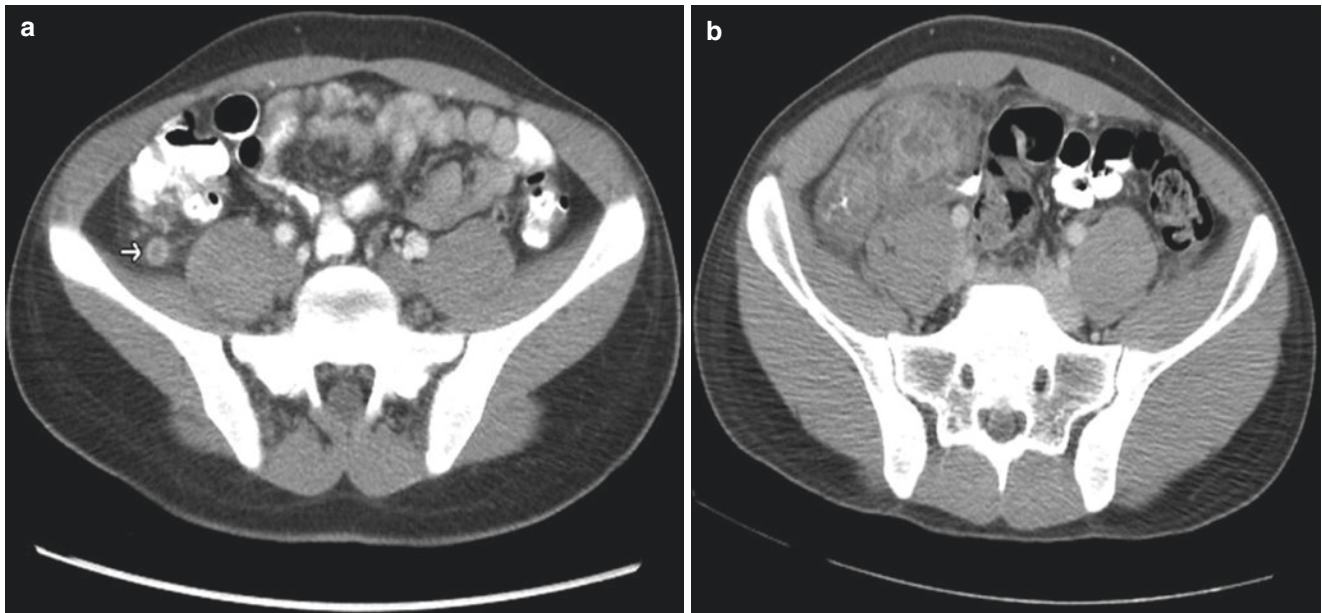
(a) A target sign on CT scan of the abdomen and pelvis consistent with acute appendicitis. (b) Periappendiceal inflammation suspicious for perforated appendicitis
